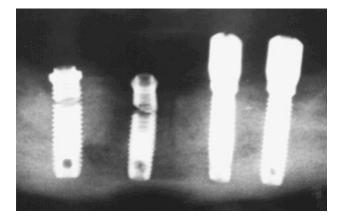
Radiograph of mechanical implant fractures.
